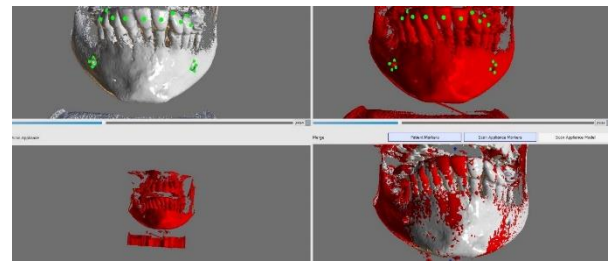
This figure shows the superimposition process of the pre-operative and post-operative CBCT.
